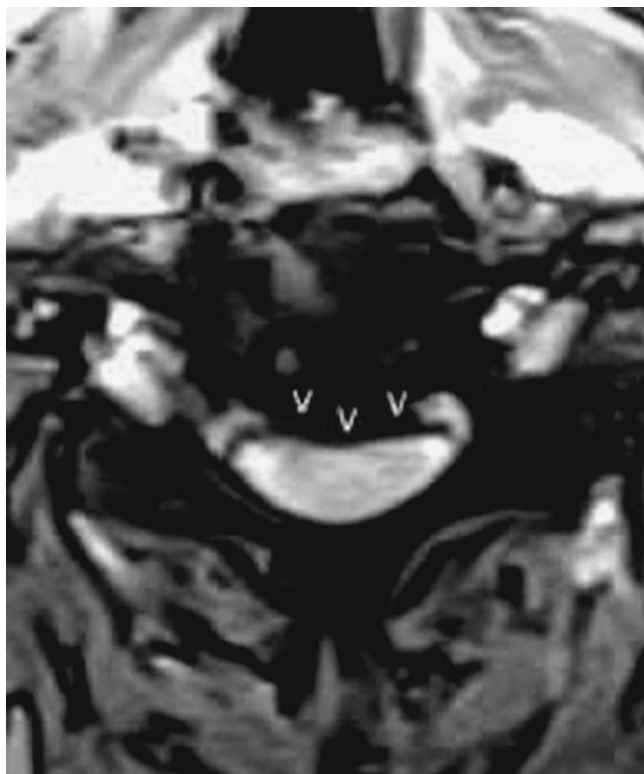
Axial T2-weighted MRI image at a stenotic level. Note the loss of CSF signal (V V V) surrounding the cord. See text for more information.
